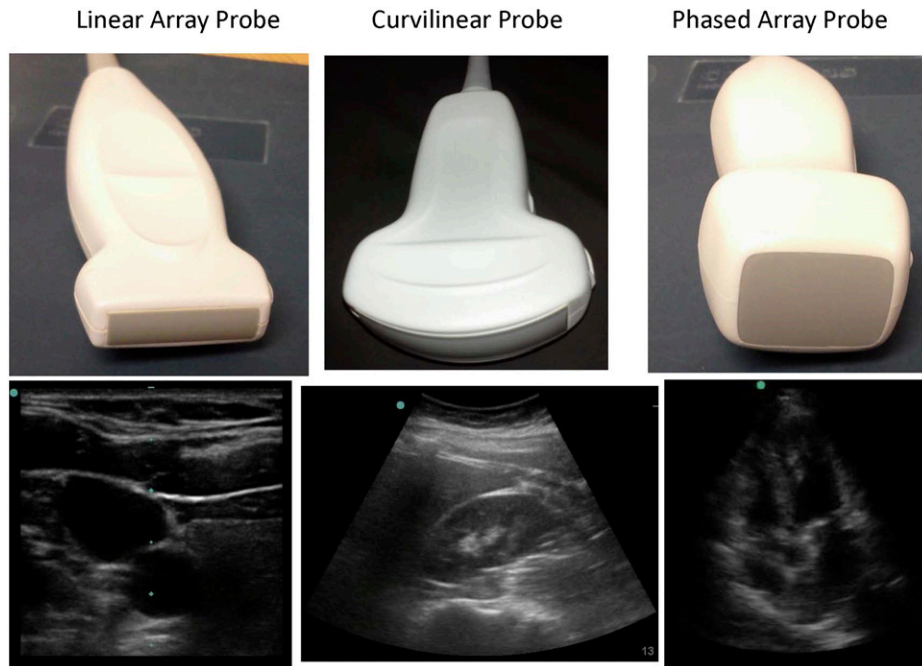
Ultrasound probes. Examples of the three types of probes used in critical care ultrasonography, with a corresponding example of an image from each type of probe.
